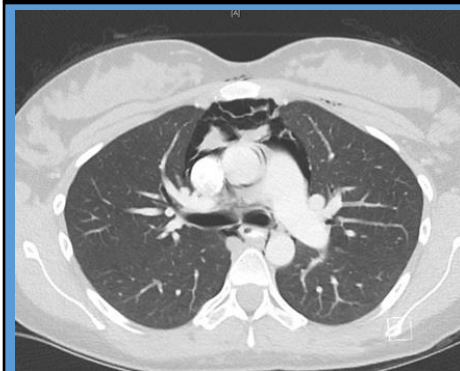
CT demonstrating pneumomediastinum
